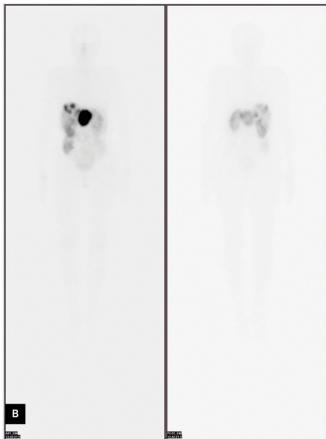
Post-therapeutic planar whole-body scintigraphy images after the first (A) and after the fourth (B) [177Lu]Lu-DOTA-TATE course
